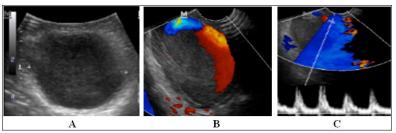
Ultrasound image, B mode (A), color Doppler mode (B), and pulsed Doppler mode (C): Oval, thin-walled formation with particulate hypo echoic content, showing the "yin-yang" sign on color Doppler and arterial flow on pulsed Doppler
